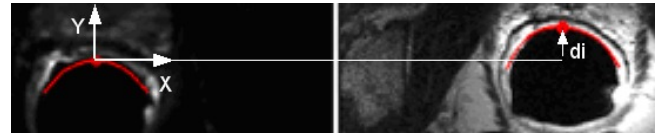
Spline curves superimposed on DWI (left) and T2w (right), and initial displacement between DWI and T2w near the coil.
